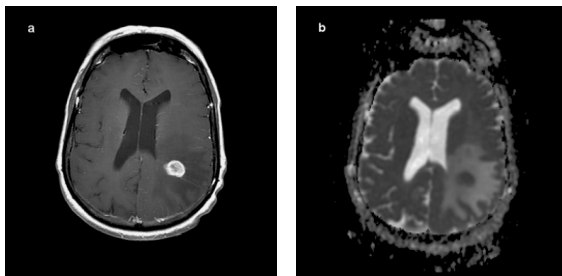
Glioblastoma multiforme (WHO grade IV) in a 60-year-old woman. a Post-contrast T1-weighted image shows an enhancing mass in the left parietal area. b ADC map (minimum ADC tumor value) shows strongly hypointensity in the lesion ($0.566 \times 10^{-3} \text{ mm}^2/\text{sec}$). This finding may correspond to the cellularity of the tumor.
